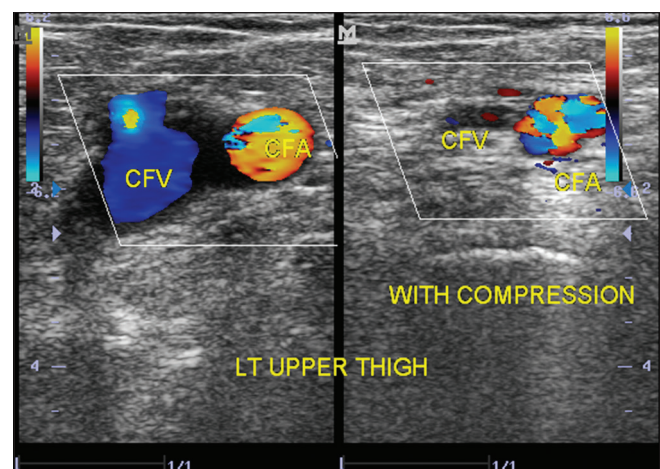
Axial section of color Doppler sonogram of the left groin/upper thigh showing normal compressibility of the common femoral vein, thus signifying a patent lumen
